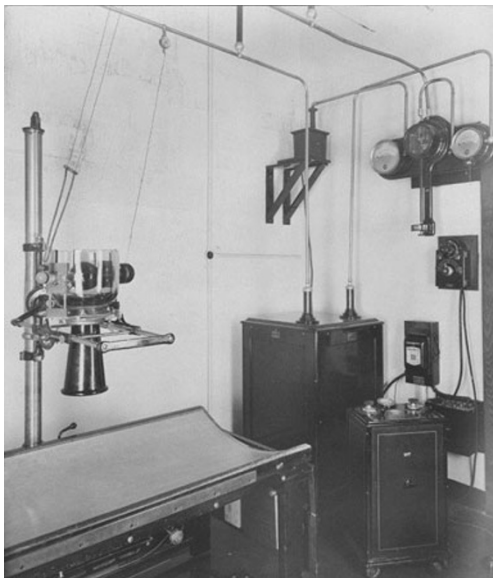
Overhead tubing to excite Coolidge X-ray tube. Double wires to the left supply power for hot cathode and cathode potential, right wire for anode (Collection of Dr. D.O. Cuscela)
